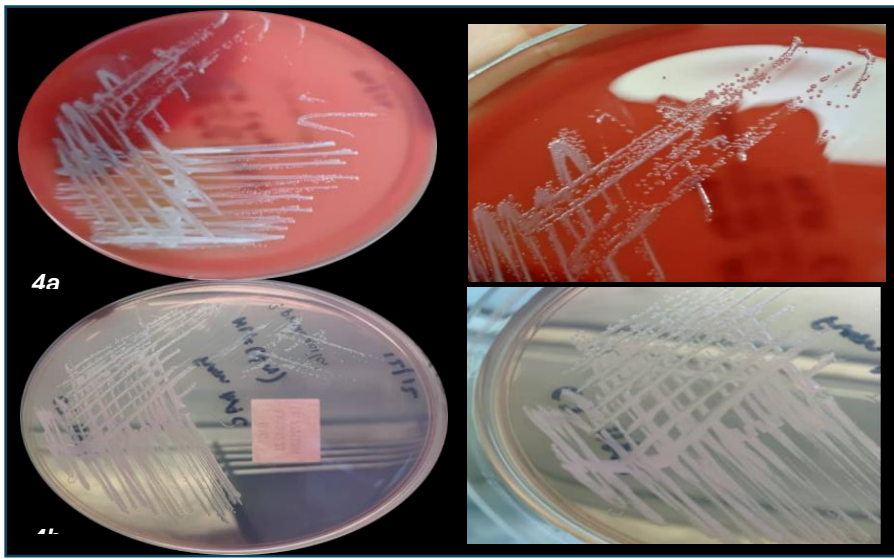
(a) On blood agar, *B. pseudomallei* colonies are cream coloured, and produced a metallic sheen at 24 hours incubation. The colonies will become more pinkish, dry, and wrinkled after 24 hours incubation. 4(b) On MacConkey agar, *B. pseudomallei* colonies grow as tiny, non-lactose fermenters seen as opaque, colourless with a metallic sheen initially, but after 48 hours, will become more pinkish as it takes dyes from the medium. Ultrasonography of the abdomen and chest x-ray were also performed to rule out any deep-seated or localised abscess, but they were negative.
